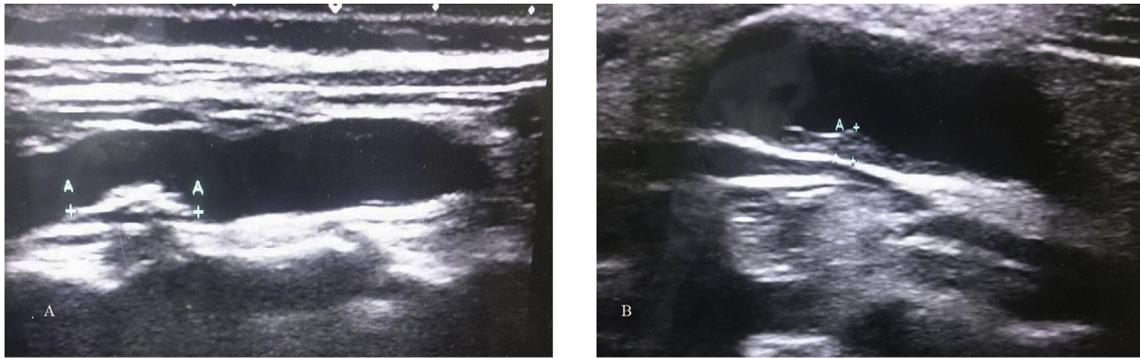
Carotid ultrasound in a patient with NAFLD revealed atheromatous plaque (A) and increased carotid intima-media thickness (B).
